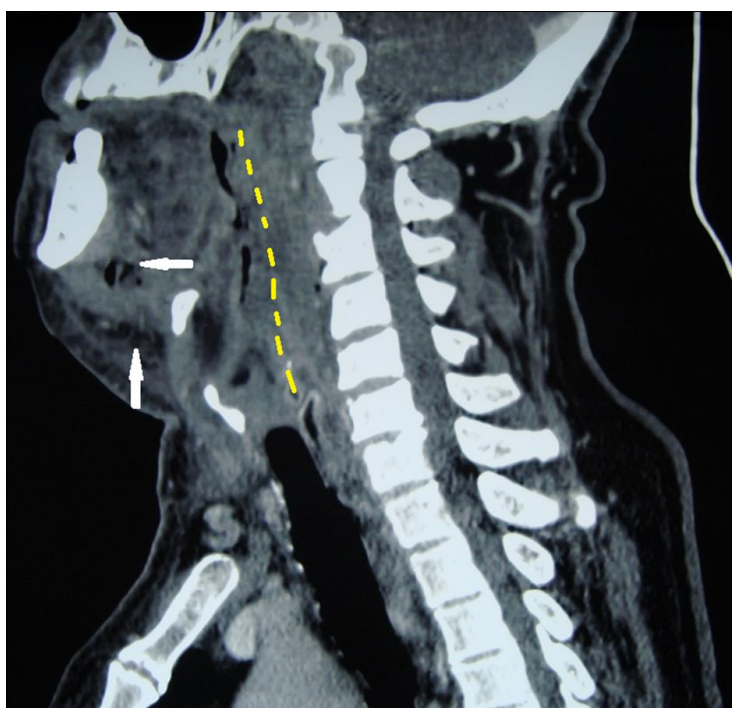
Computed tomography, Sagittal view. Narrowing of the airway tract from the retropharyngeal space up to the retrosternal level (Yellow discontinued line). Supra and infra-mylohyoid gas formation (arrow).
